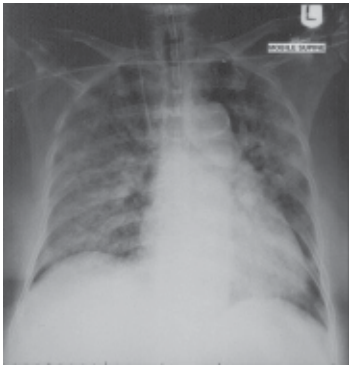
Chest radiograph of the patient when she developed pulmonary haemorrhage. Bilateral alveolar infiltrates are seen.
